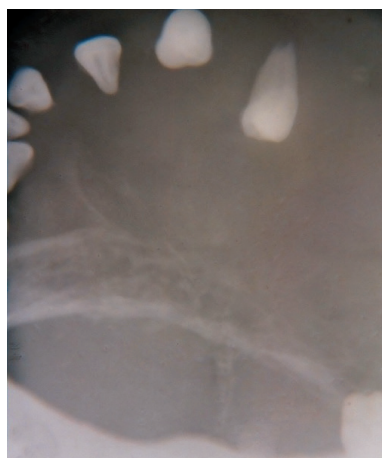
Occlusal radiograph showing labially displaced anterior teeth giving floating teeth appearance.
